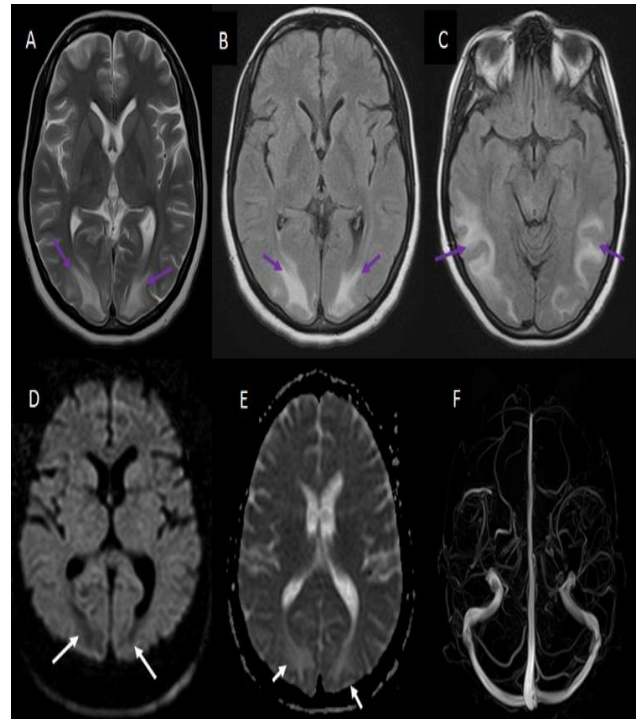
(A-F): A 32-year-old female presented with headache and seizure on the second day of post-cesarean delivery. MR imaging showed typical features of PRES: Axial T2W (A), axial FLAIR (B), axial FLAIR (C), axial DWI (D), axial ADC (E) and MRV (F).
